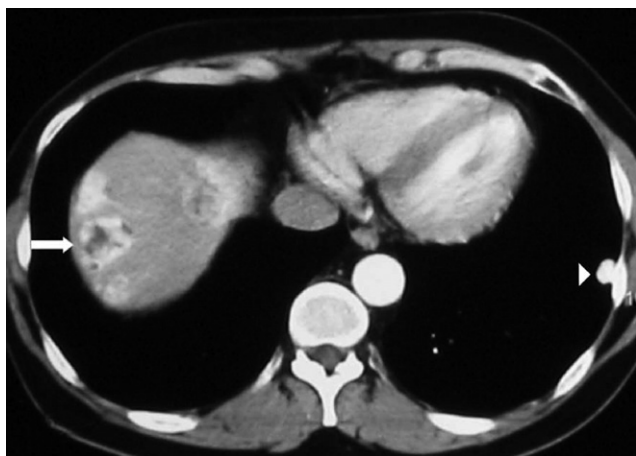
Axial contrast-enhanced CT image shows multiple hypervascular hepatic (arrow) and a lung metastasis (arrowhead) from clear cell carcinoma in a patient with VHL syndrome.
